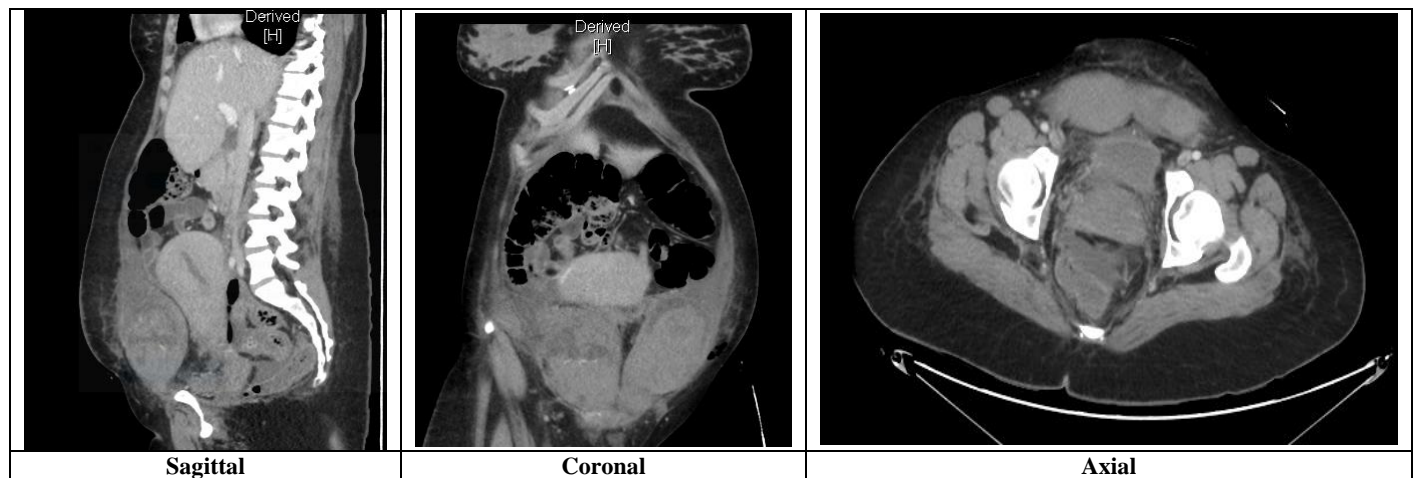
Pelvis-abdominal CT scan of patients shows bilateral rectus sheath hematoma.
